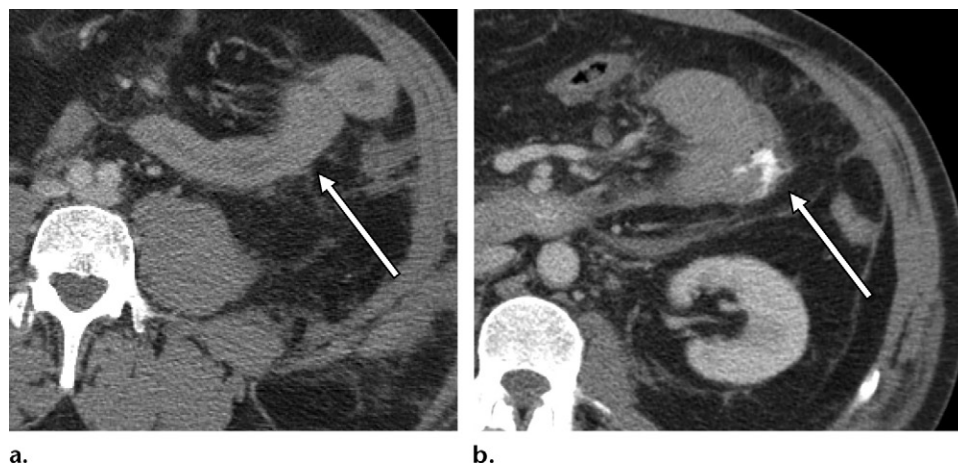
Discontinuous bowel wall in a 50-year-old man who sustained blunt abdominal trauma in a boating accident. (a) Axial contrast material–enhanced CT image through the abdomen (a obtained at a lower level than b) shows thickened loops of jejunum (arrow). (b) Axial contrast-enhanced CT image shows a small area of bowel wall discontinuity in the mid jejunum, with leakage of oral contrast material (arrow). A splenic laceration and hyperattenuating free fluid in the pelvis were also seen (not shown). At laparotomy, a small-bowel perforation was confirmed that required resection. A left hemicolectomy was also performed, and a cecal tear required primary repair.
